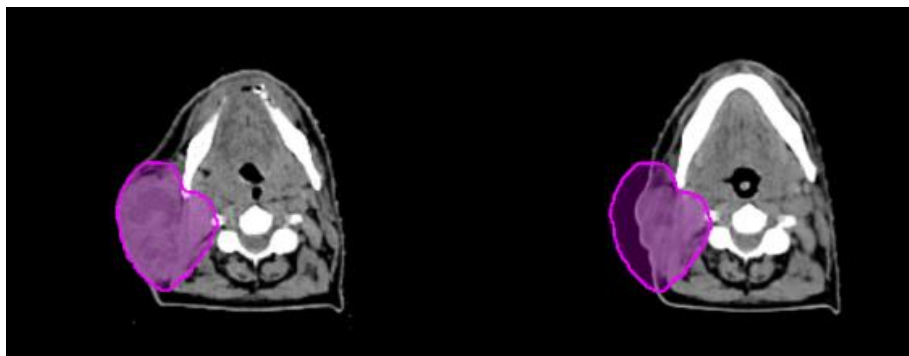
In the right side of the image, the planning CT and tumour contour for a given H&N patient is shown. In the left side, a repeat CT for the same patient acquired 2 weeks after the beginning of treatment.
